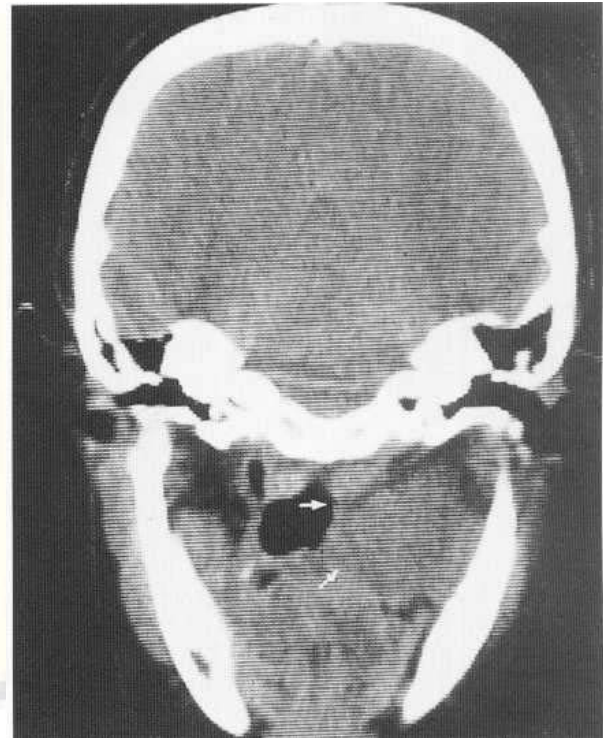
Coronal CT section showing a pleomorphic salivary adenoma of the deep parotid lobe bulging into the nasopharynx and depressing the soft palate (arrows). Note the way the pharyngeal muscles are displaced medially by a well-defined mass, indicating that this adenoma did not arise from an accessory pharyngeal salivary gland.
